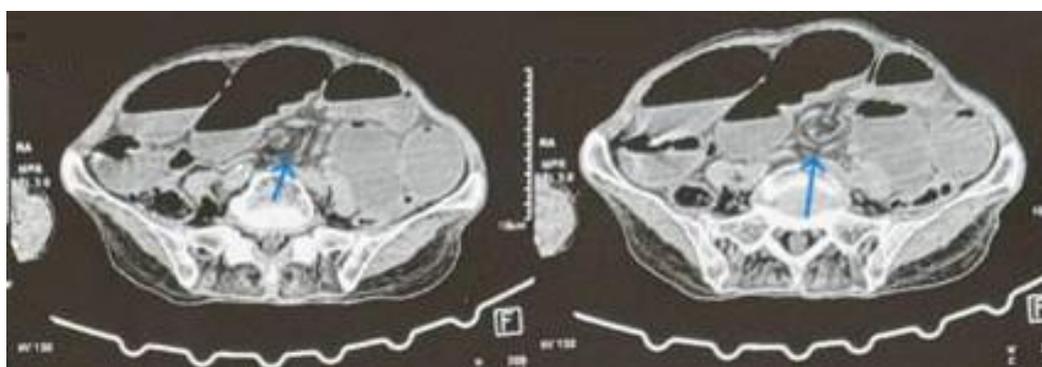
CT image showing the spiral appearance of vessels and beak-like transition. Blue arrow
